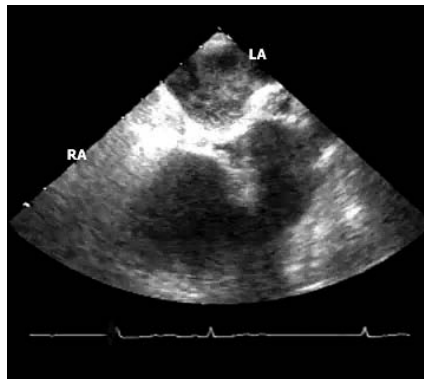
Patent foramen ovale discovered by transesophageal echocardiogram. LA, left atrium; RA, right atrium. www.medreviews.com
